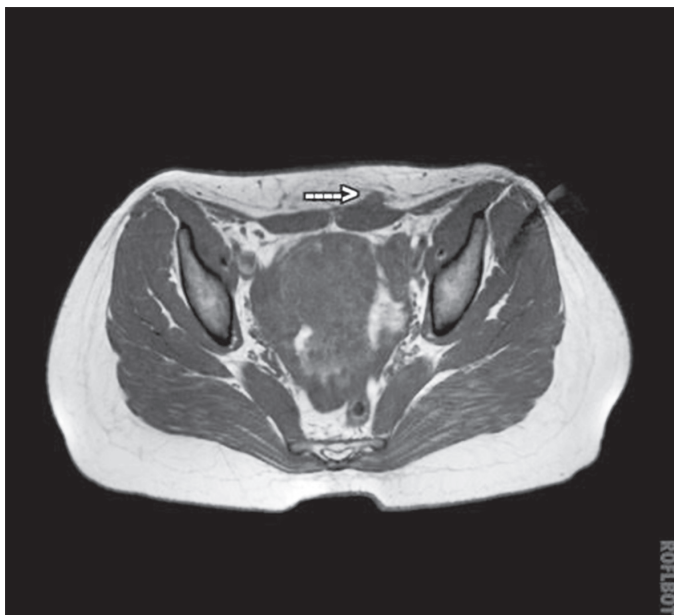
Magnetic resonance image axial
